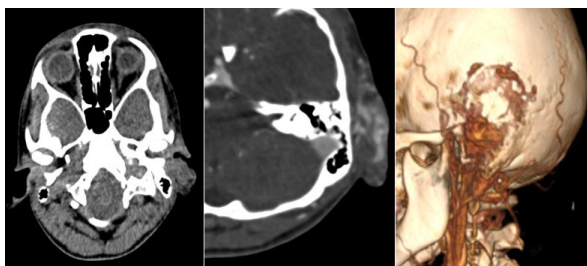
Computed tomographic angiography before (A) and after (B) contrast injection and in 3D reconstruction (C): Thickening of the left pinna extending into the external auditory canal with individualization of several serpiginous vascular structures within it after injection of contrast agent.
